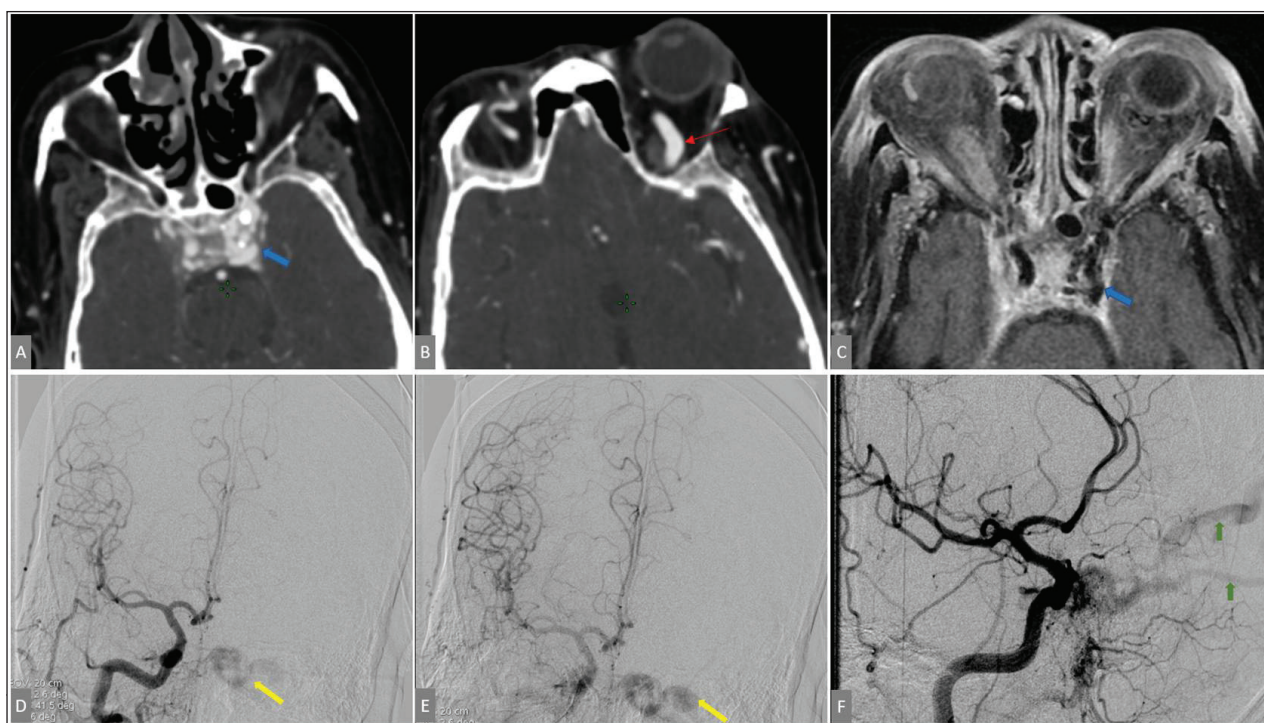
A 46-year-old man with a history of hypertension and diabetes, presenting with a 2-day history of headache and left eyelid ptosis. Axial contrast-enhanced CT in the arterial phase (a, b) demonstrates early opacification of the left cavernous sinus (a) and dilatation of the left superior ophthalmic vein (b), suggestive of a carotid-cavernous fistula. Axial T2-weighted fat-saturated MRI (1.5 T) (c) shows serpiginous flow voids within the left cavernous sinus, reflecting arteriovenous shunting. DSA performed during opacification of the right internal carotid artery (d–f) confirms early filling of the left cavernous sinus (yellow arrow) with retrograde drainage through both superior ophthalmic veins (green arrows), consistent with a spontaneous dural carotid-cavernous fistula. All images are fully anonymized and reproduced with written patient consent.
